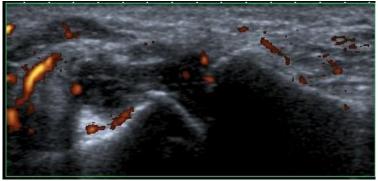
Volar synovitis doppler positive - MCP 2 joint
